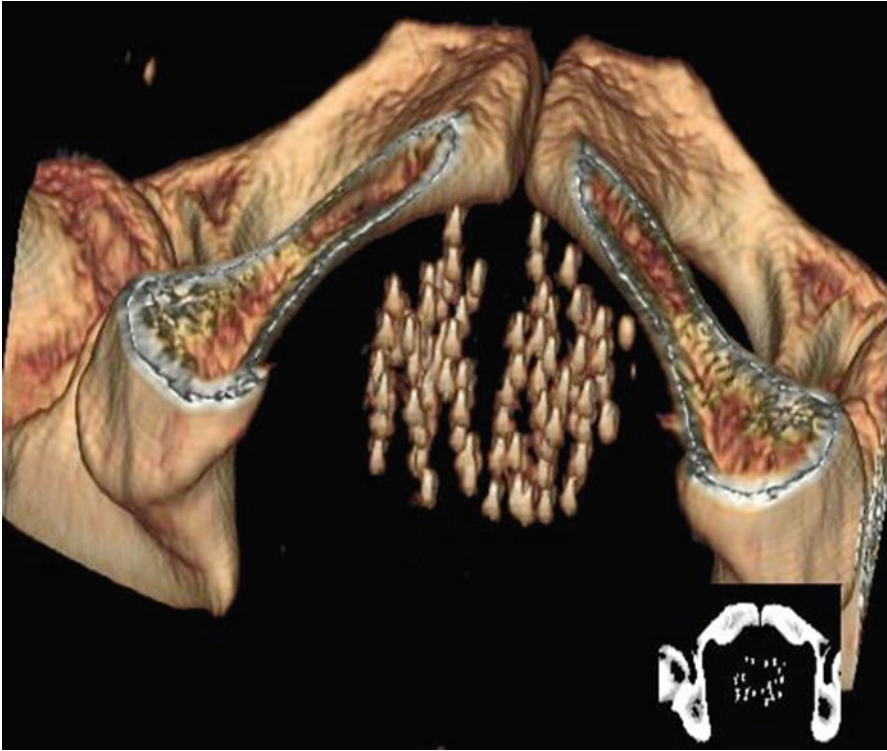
Volumetric CT to show 3D source cloud
